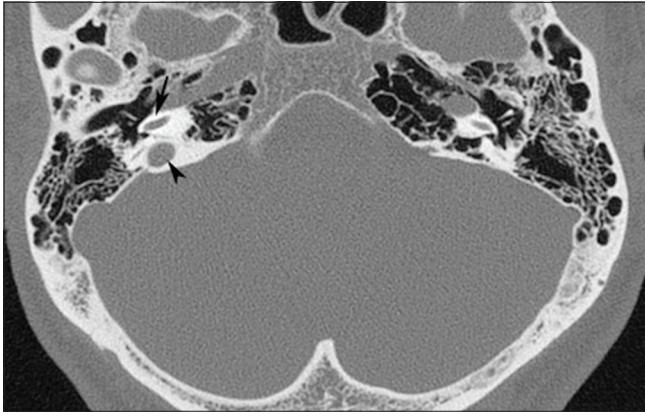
A 24-year-old woman with high riding jugular bulb. Axial high-resolution computed tomography image shows jugular bulb (arrowhead) at the level of the basal cochlear turn (arrow).
